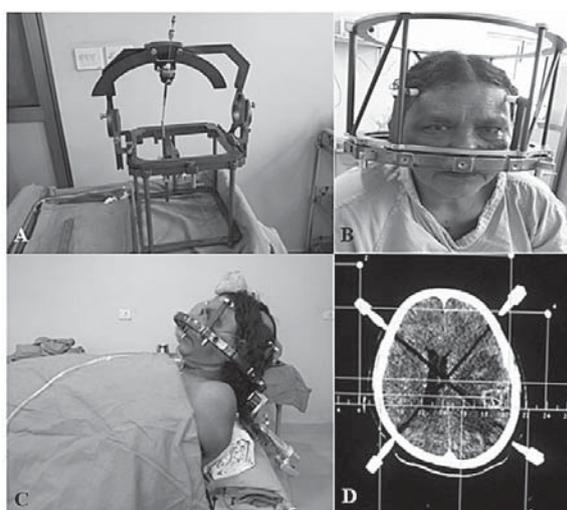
Stereotactic procedure. A) Leksell Frame, B) fixation of Leksell frame, C) patient is ready for the procedure, D) CT scan after fixation of the frame and before the procedure
